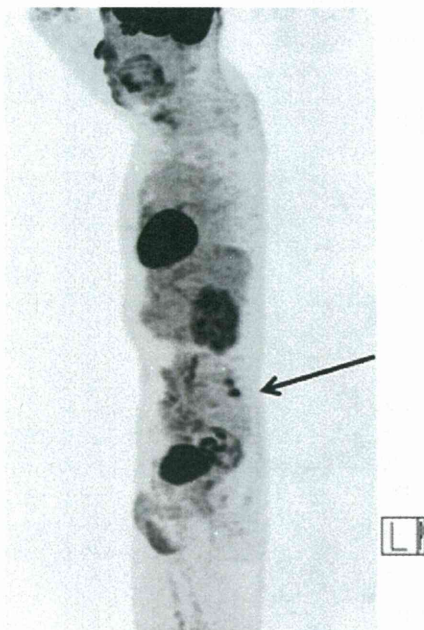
FDG-PET scan of Case 1 performed at the same time (09/28/2009) as the previously reported Fig. 1D (Nakajima et al. [16]) shows bone metastasis of the left vertebral arch of L5 (arrow) in a sagittal view.
